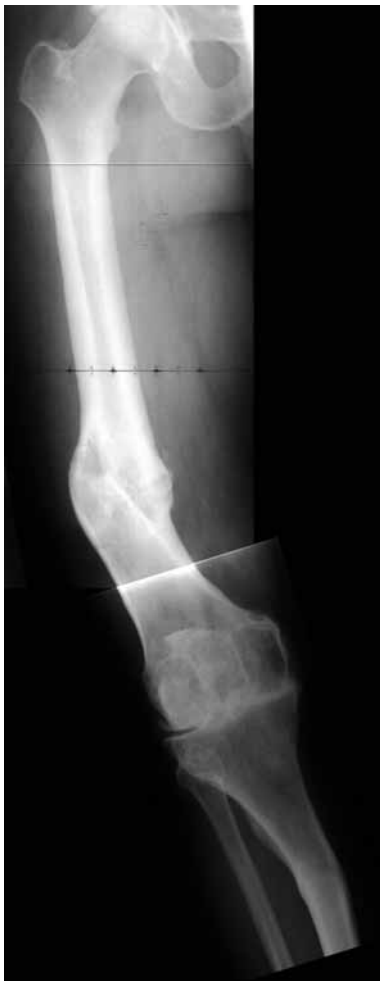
Right knee, preoperative AP radiograph.
